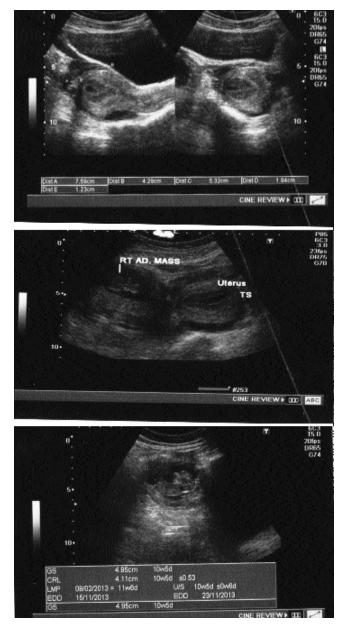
Ultrasound images showing extra-uterine pregnancy and empty uterus.
